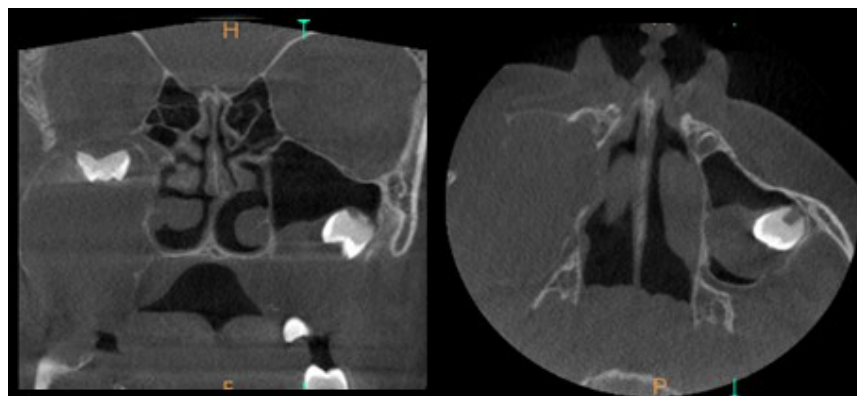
CBCT images showing multiple odontogenic keratocyst in the maxilla and the mandible
